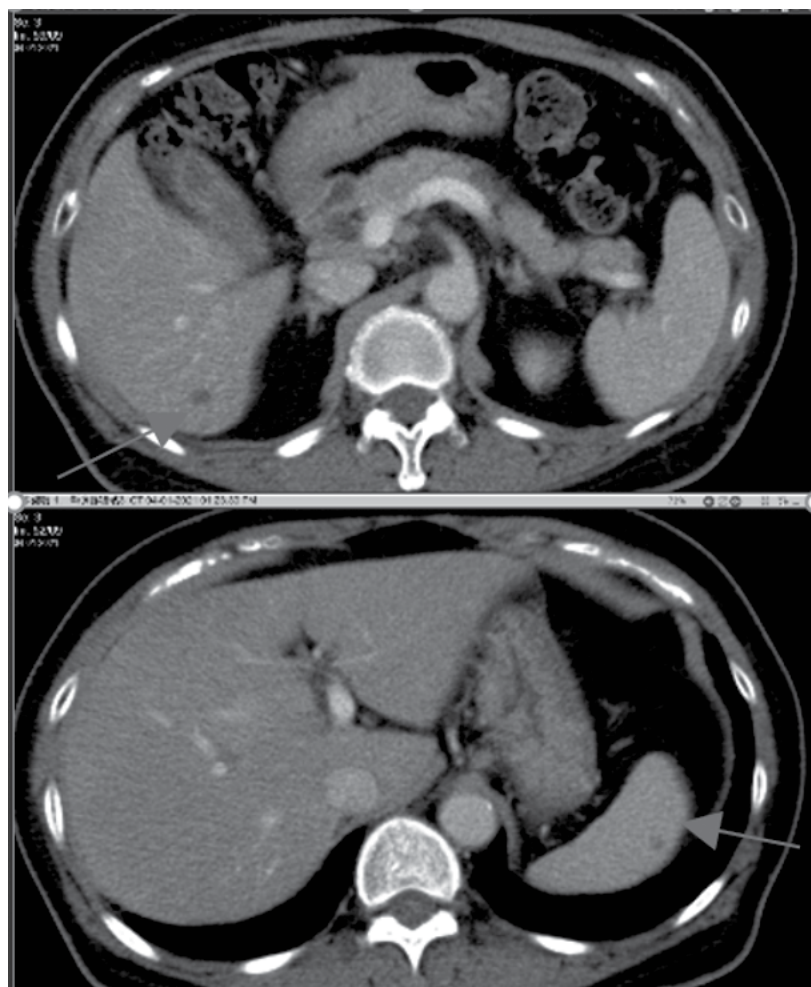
Chest CT scan including upper abdomen shows hypoattenuating lesions in right hepatic lobe and spleen, suspicious for granulomata (blue arrows).
